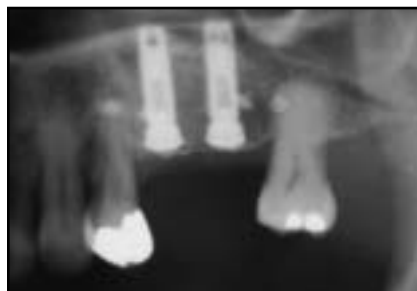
(left) Radiographic control after 13 months of healing, just before membrane removal.
